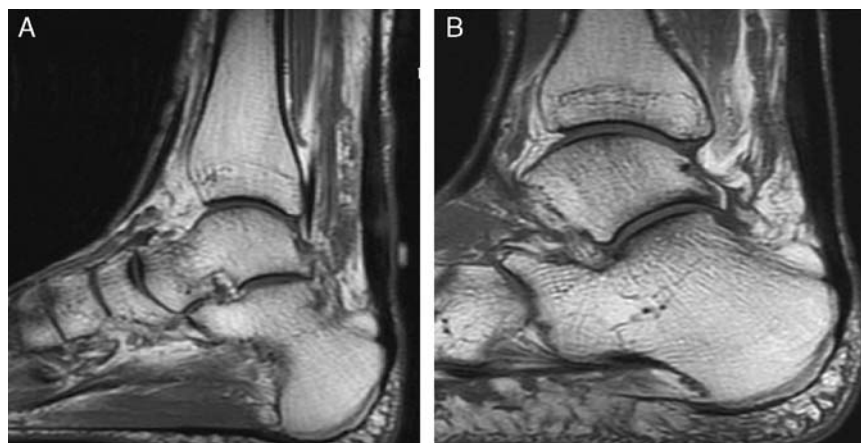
A, Case of a midsubstance partial tear of the Achilles tendon before PRP treatment. B, Same patient after PRP treatment. Achilles lesion resolved on MRI to a mild-moderate tendinosis. The patient has returned to sports and is pain free. PRP indicates platelet-rich plasma.
